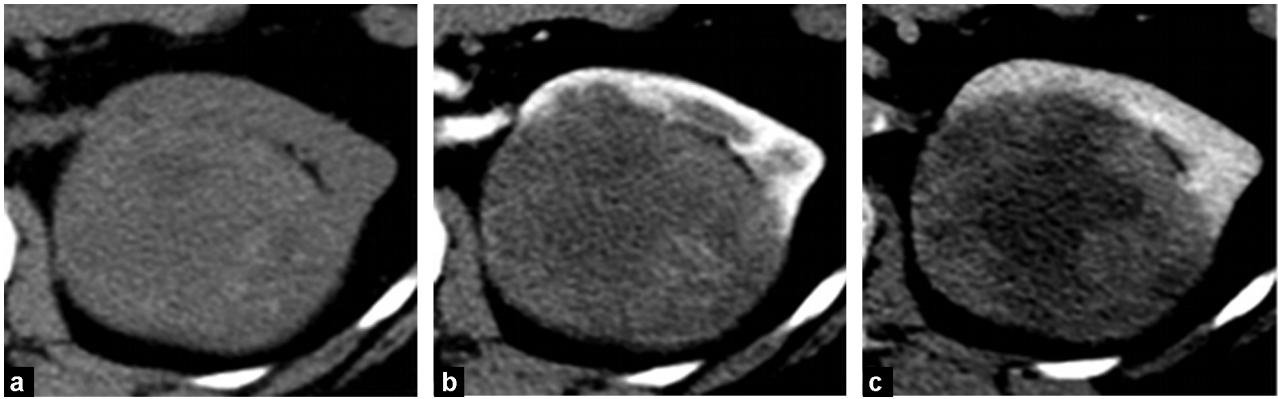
Massively necrotic heterogeneous papillary carcinoma. CT: a: before enhancement; b: arterial phase; c: tubular phase.
